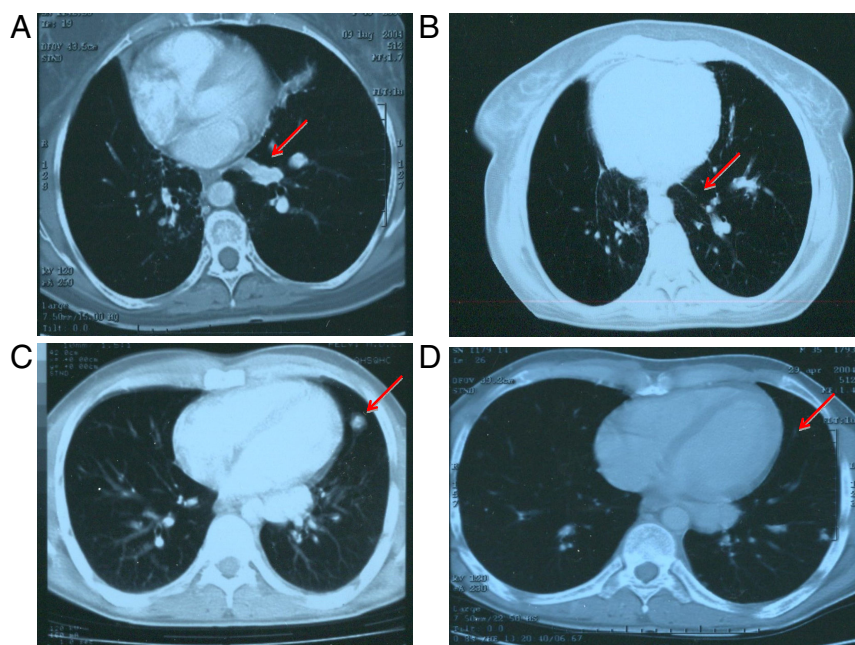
Chest computed tomography scans in patients 1 (A and B) and 2 (C and D), before (A and C) and 6 months from the beginning of the therapy (B and D) with LAN and sc low-dose human recombinant IL-2. A dramatic shrinkage of metastatic lesions (red arrows) was observed in both patients after biological therapy.
